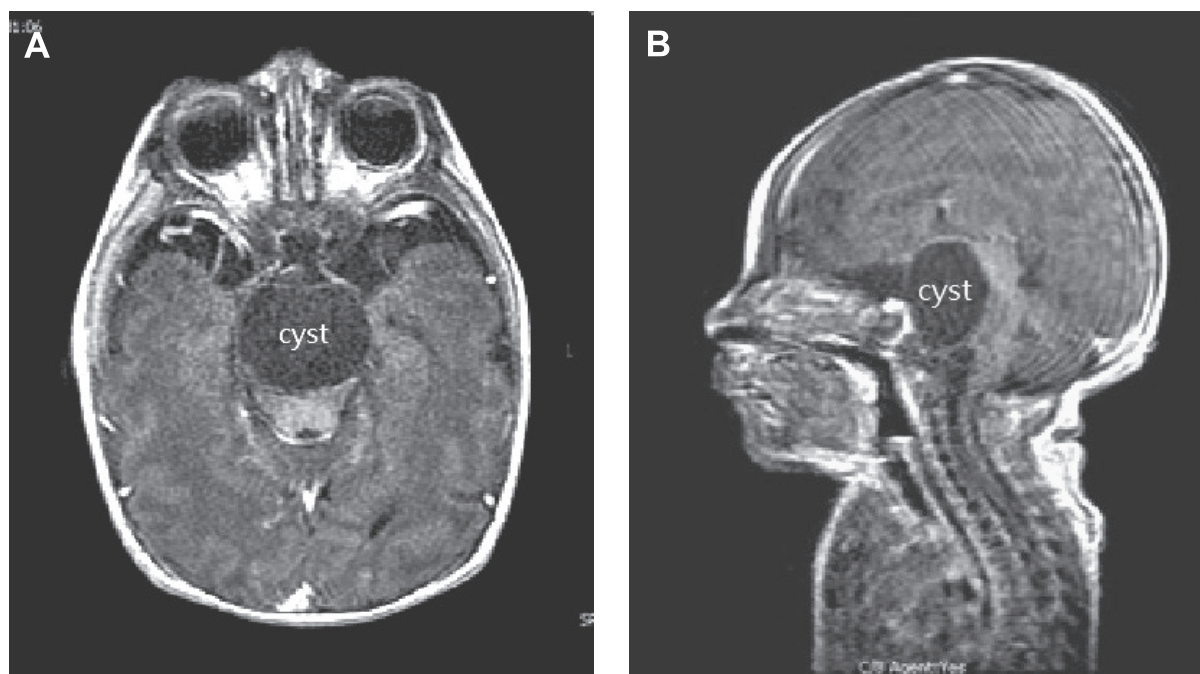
(A) and (B) brain MRI revealed (1) A relatively well-defined, non-enhanced cystic lesion (measuring approximately 18 mm × 28mm in dimension) is located at supra-sellar region that results in external compression to midbrain posteriorly displacement. (2) Bil. middle cranial fossa arachnoid cysts are likely. (3) Small amounts of subdural effusions at posterior fossa.
